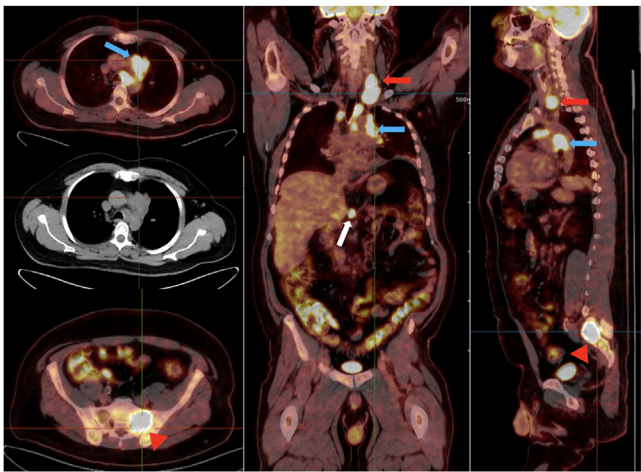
Baseline [¹⁸F]FDG PET/CT images of a 47-year-old male with PD-L1 positive NSCLC. Baseline [¹⁸F]FDG PET/CT images demonstrate neoplastic adenopathy in the neck (red arrows), intrathoracic (blue arrows), and abdominal nodes (white arrow); with left sacrum lytic osseous metastases (red arrowhead). There is non-avid atelectasis in the left lower lobe (not highlighted) but no [¹⁸F]FDG-avid lesion is seen in the lung parenchyma.
